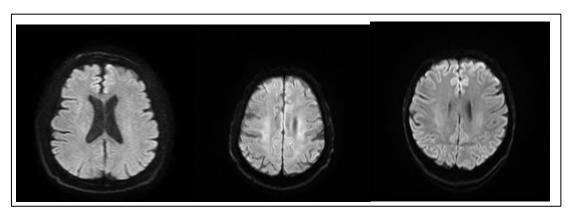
MRI Scan of a Healthy Person from NTUA Parkinson Dataset
